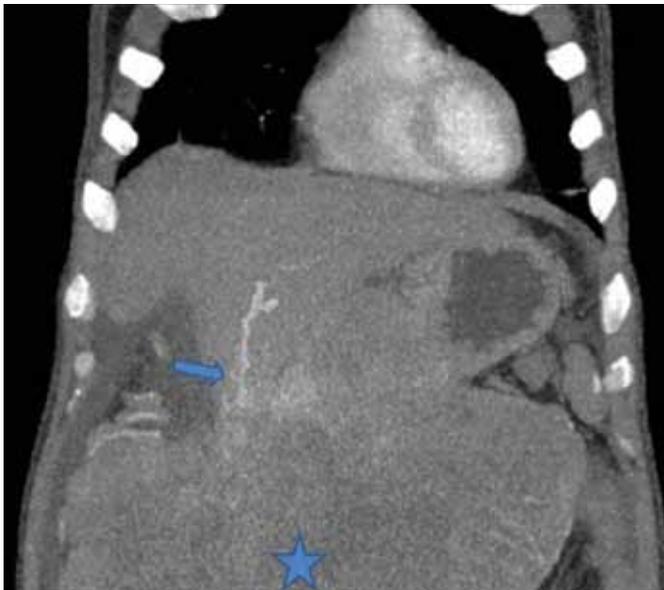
Coronal reformation image of multi-detector computed tomography. The large mass lesion shows continuation with the parenchyma of the left hepatic lobe. The prominent feeding vessel originating from the left hepatic artery is clearly shown (arrow).
